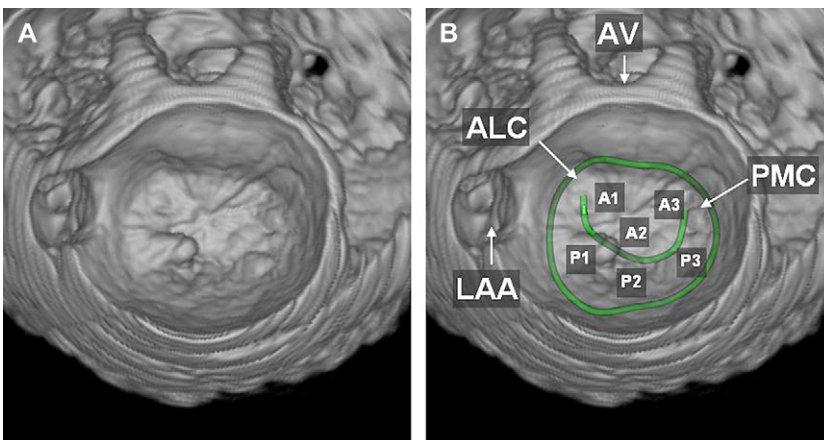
(A) Transesophageal 3D reconstruction of a prolapsed (P1) mitral valve. (B) The morphological assessment can be simplified by visualizing the mitral valve annulus and the coaptation line into the volume-rendered image (TomTec 4D MV-Assessment CAP, TomTec Imaging Systems, Unterschleissheim, Germany). (B) The major anatomical structures can be labeled automatically if required. *Abbreviations:* ALC, anteriolateral commissure; AoV, aortic valve; LAA, left atrial appendage; PMC, posteriomedial commissure. A1-A3 and P1-P3 refer to the three scallops of the anterior (A) and posterior (P) leaflet.
